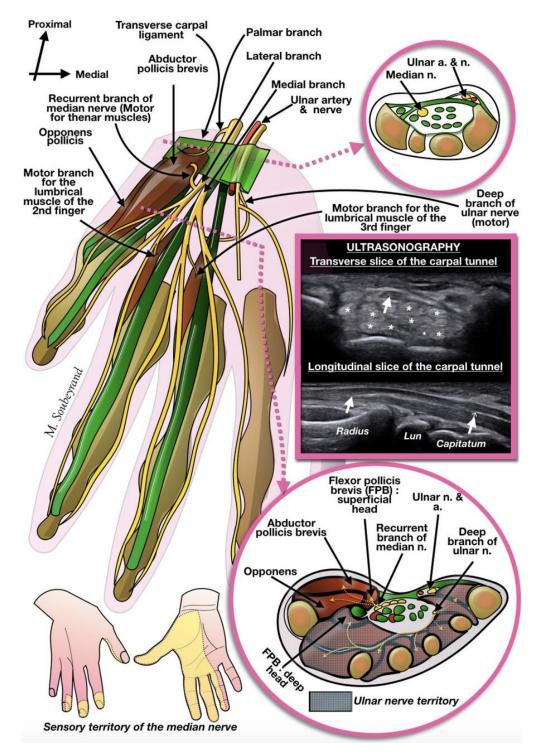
Anterior view of the distribution of the median nerve in the hand. Transverse slices at the carpal tunnel and in the palm along with corresponding ultrasonography images (Soubeyrand et al., 2020).
